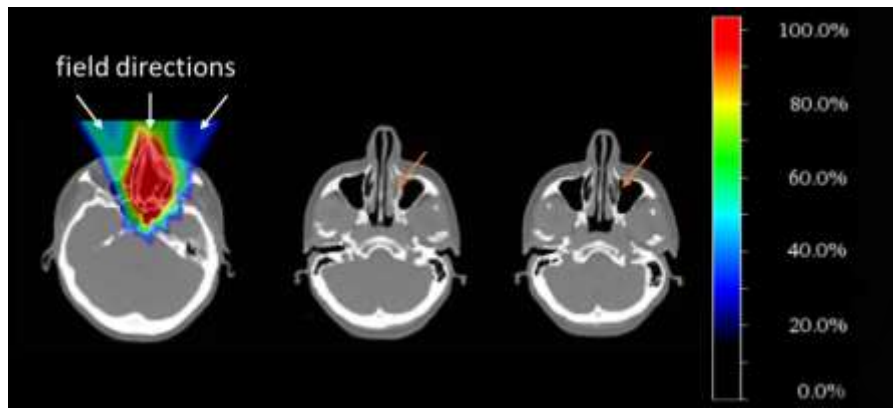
Target dose distribution on planning CT with PTV outlined in white and indicated field incident directions (left) and two repeat CTs (middle and right) with small changes in the nasal cavity fillings indicated with orange arrows. The color wash scale of the dose in % of the prescription is displayed on the right-hand side of the figure.
